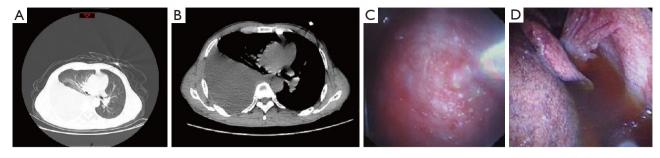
Chest CT and thoracoscope of local hospital. (A,B) Chest CT scan: local thickened right pleura and bulk hydrothorax. (C,D) Thoracoscope: dark brown hydrothorax, congestive visceral pleura, and multiple intensive follicles of the diaphragm dome. CT, computed tomography.
